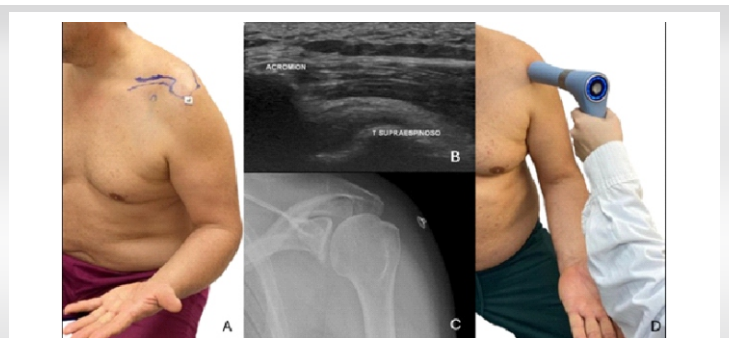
(a) "Asking hand position." (b) Ultrasound view of the anterior fibers of the supraspinatus. (c) Radiological image with the arm in the same position. Metal mark indicating the area of application. (d) Application area.
